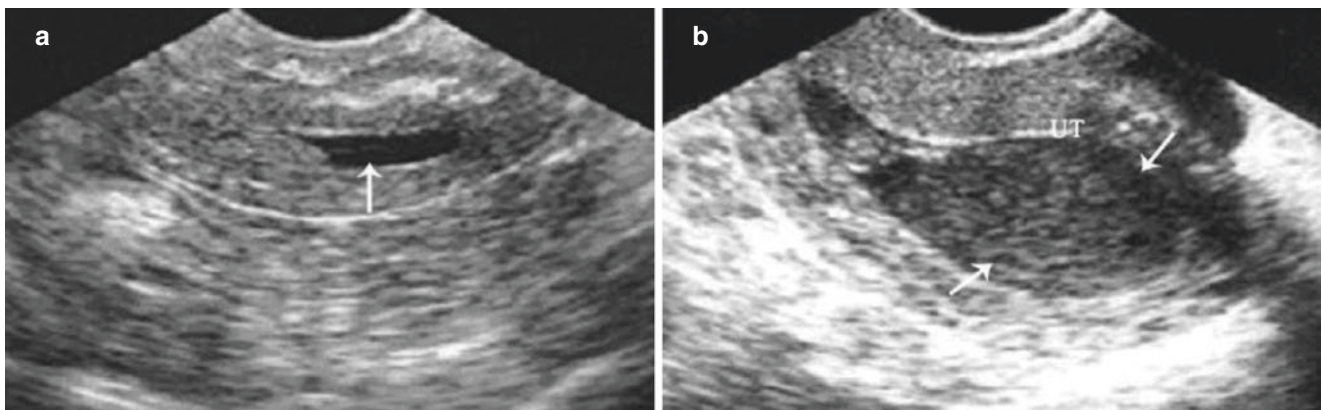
Endometrial carcinoma (IV). (a) A 65-year-old patient, with a postmenopausal period of 10 years, represented mild vaginal bleeding. Ultrasonographic image shows a small amount of fluid in the uterine cavity and a hyperechoic mass in the anterior wall of myometrium, with a diameter of nearly 1.5 cm. (b) A patient with a postmenopausal
